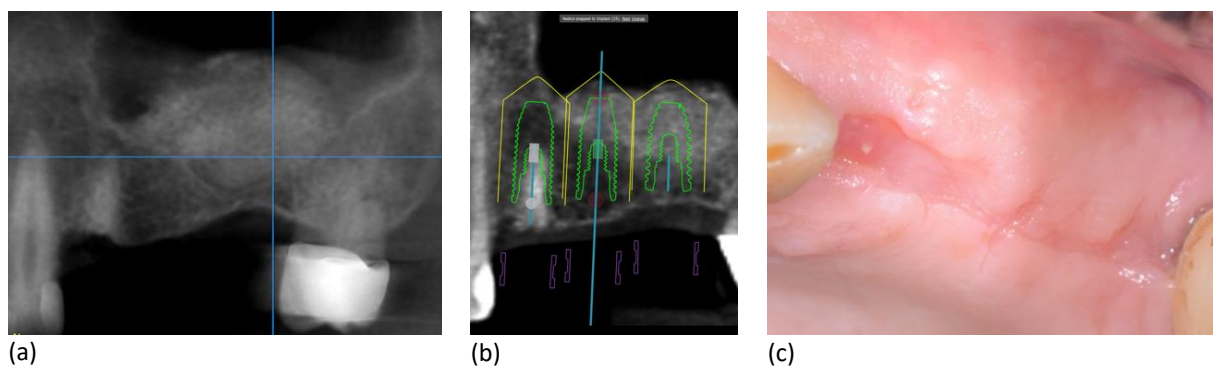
Patient 4: (a) CBCT and homogeneous cerabone® osseointegration after 6 months; (b) Implant planning in the grafted sinus; (c) Healthy, firm and keratinized alveolar ridge mucosa.
